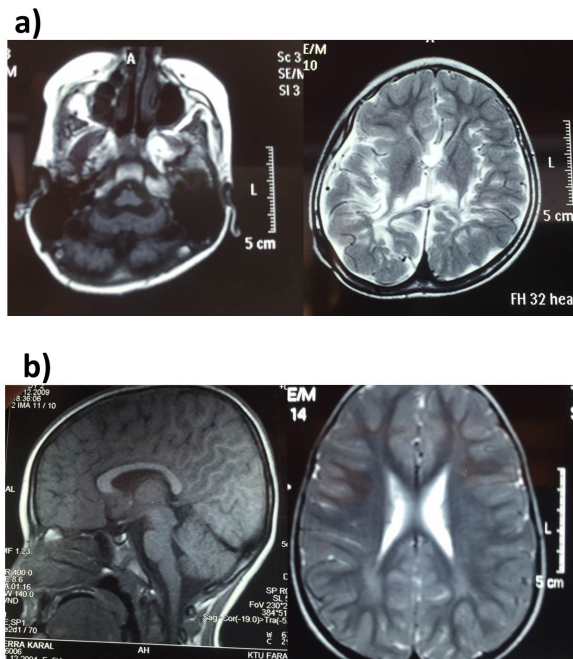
Cranial MRI findings. (a) periventricular leukomalacia and pontocerebellar hypoplasia in Case 1; (b) Periventricular hyperintensity in Case 2.
